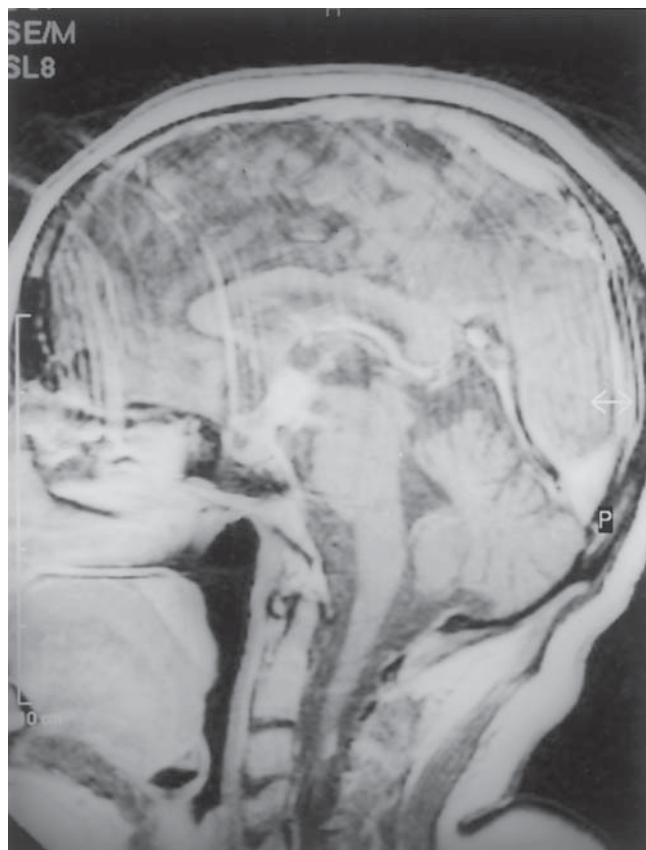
Magnetic resonance imaging (sagittal section) demonstrating marked regression of cerebral and hypothalamic lesions 1 mo after corticosteroid therapy.
